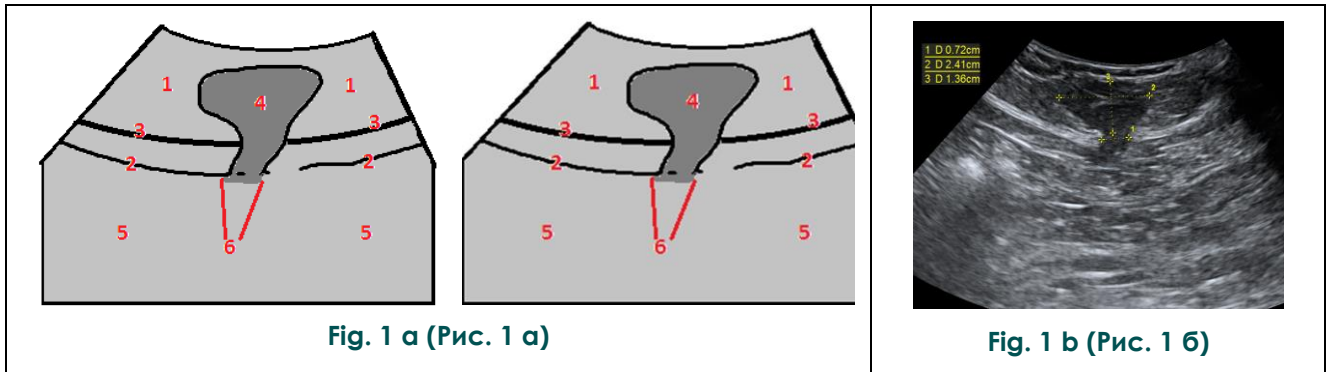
A – the chart, B – Ultrasound image. Patient T., 54 y.o. Fat containing hernia at linea alba.
